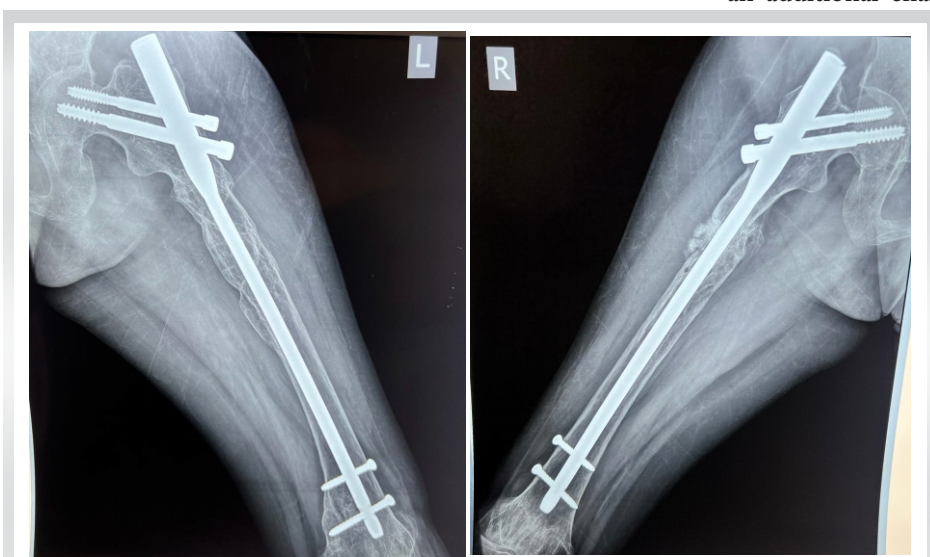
6 month follow-up radiographs of bilateral femur operated with cephalomedullary nail fixation showing fracture union.
